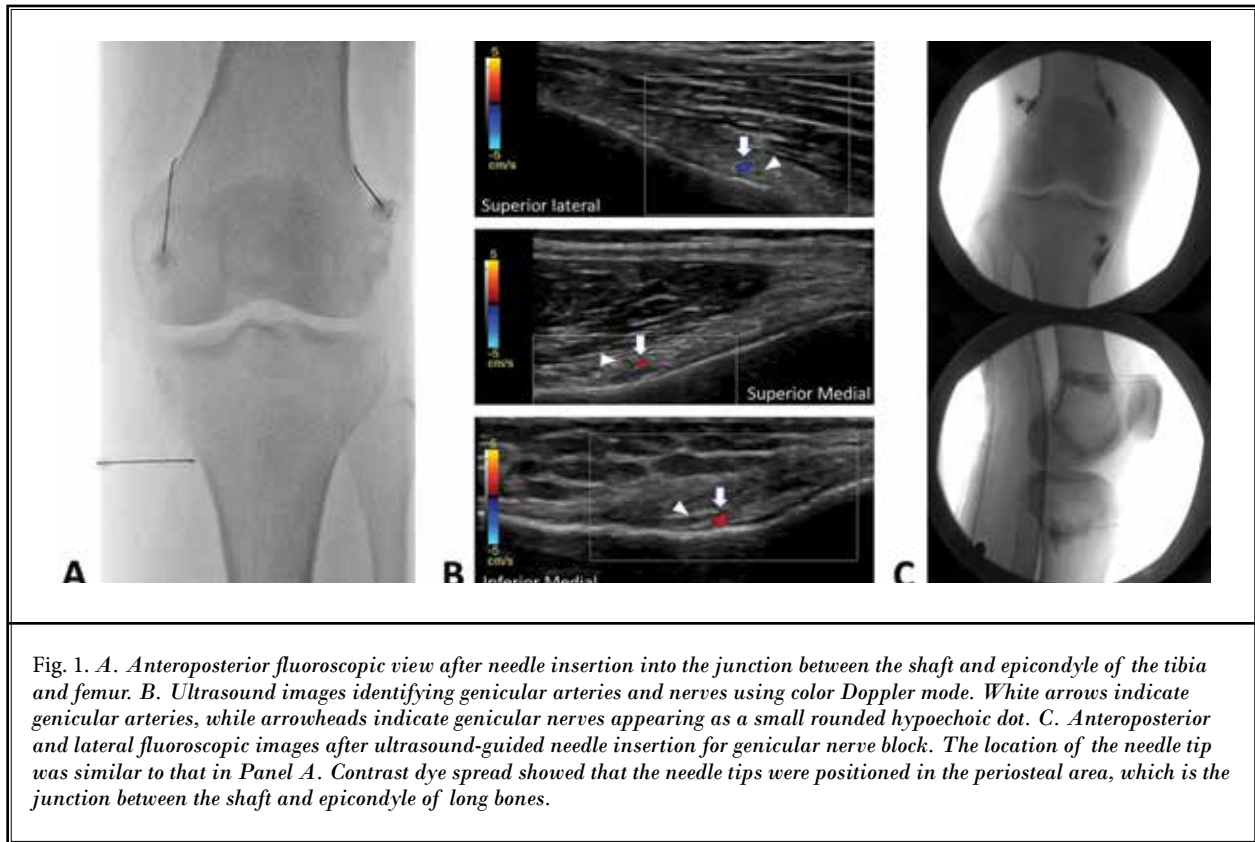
A. Anteroposterior fluoroscopic view after needle insertion into the junction between the shaft and epicondyle of the tibia and femur. B. Ultrasound images identifying genicular arteries and nerves using color Doppler mode. White arrows indicate genicular arteries, while arrowheads indicate genicular nerves appearing as a small rounded hypoechoic dot. C. Anteroposterior and lateral fluoroscopic images after ultrasound-guided needle insertion for genicular nerve block. The location of the needle tip was similar to that in Panel A. Contrast dye spread showed that the needle tips were positioned in the periosteal area, which is the junction between the shaft and epicondyle of long bones.*
